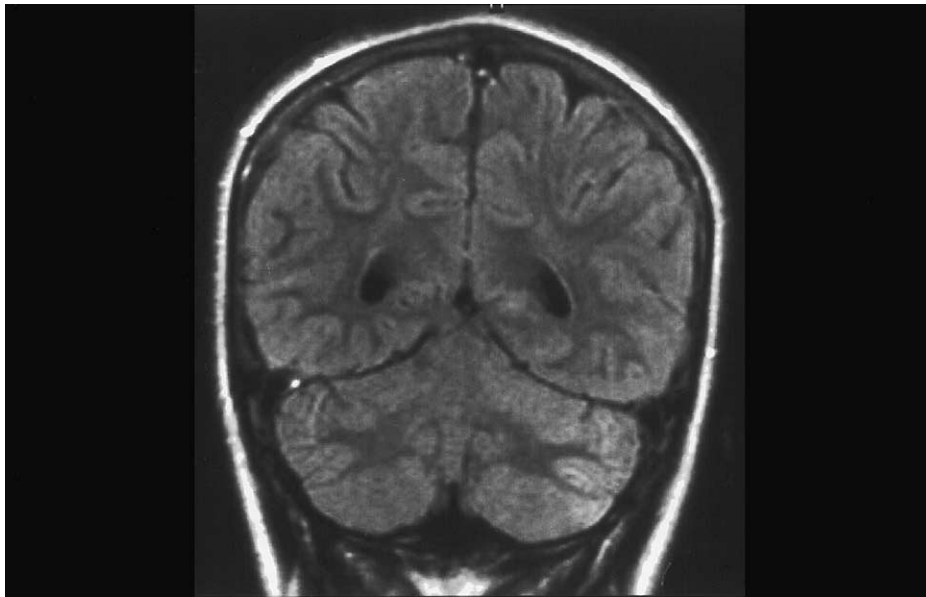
MRI coronal flair sequence showing mild hyperintensity of left cerebellar cortex, otherwise of normal volume.
